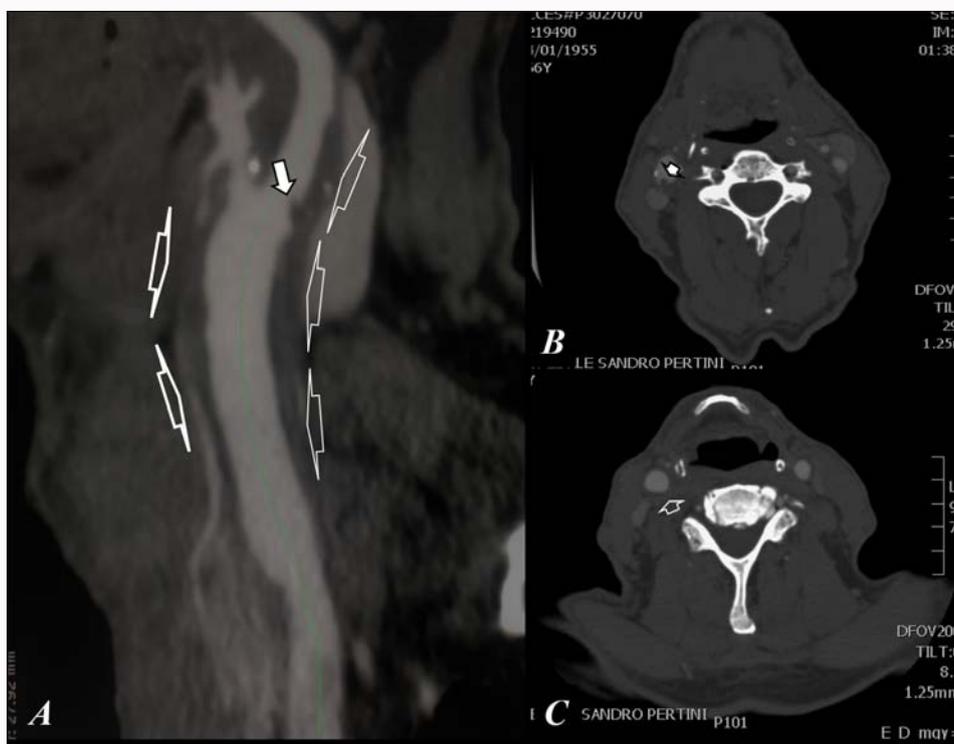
A) Note in the sagittal CTA reconstruction the extensive parietal thrombosis of the enlarged carotid bulbous (empty arrows). B,C) transversal CTA of the neck showing a moderate internal CA stenosis coupled with aFFT into the lumen of the proximal internal CA (small white arrows). FFT: Free-Floating Thrombus; CTA: CT Angiogram; CA: Carotid Artery
